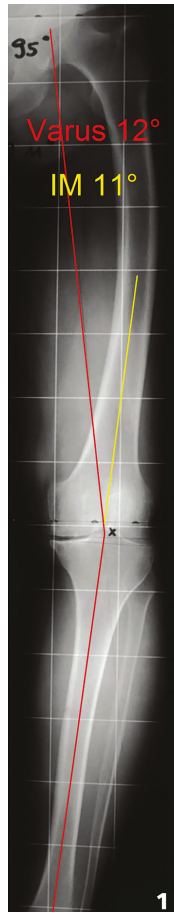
Standardized full leg weight bearing x-ray with mechanical axis femur and tibia, medial proximal tibia angle (MPTA), lateral distal femur angle (LDFA), varus deformity of 12° and IM-correction angle of 11°.
